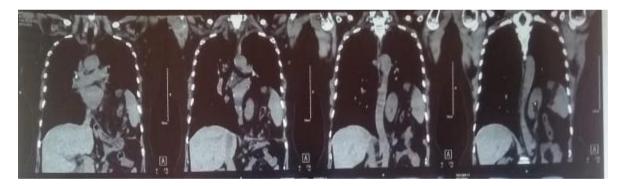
CT-Thorax (Coronal View)
